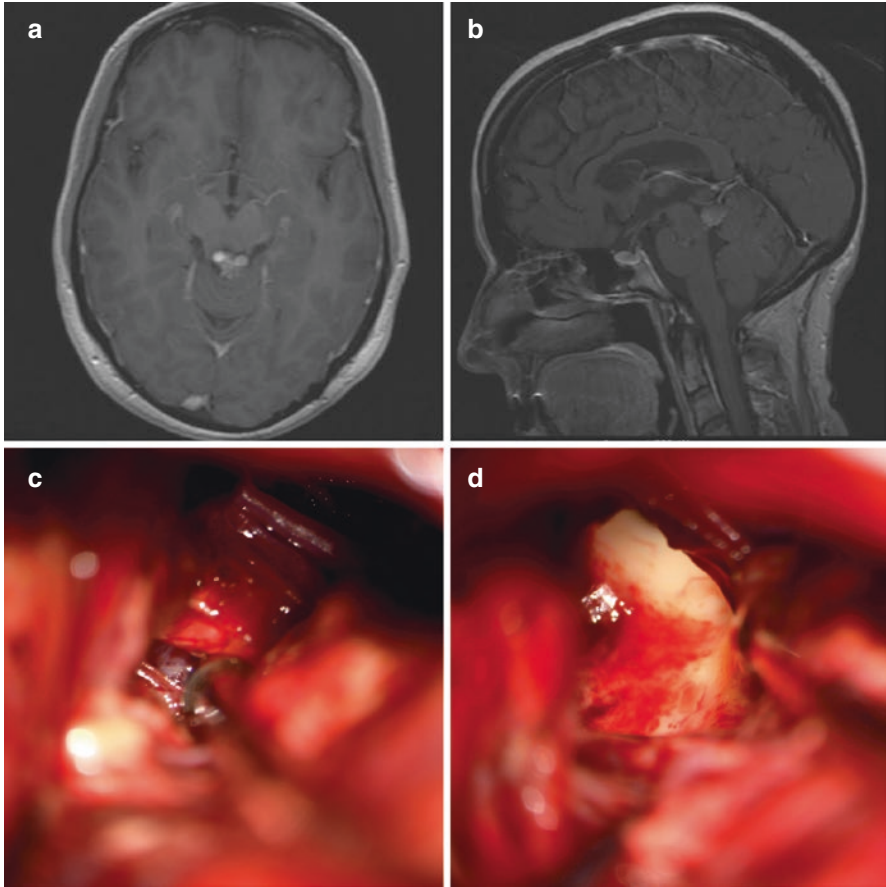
A patient presenting with diplopia and paresthesia was found to have a dorsal midbrain CM with a classic “popcorn” appearance on axial (a) and sagittal (b) MRI sequences. A supracerebellar-infratentorial craniotomy was planned to approach this lesion. Even with the patient in the sitting position, to maximize gravity retraction of the cerebellum, the CM was not completely visible. Resection of a small area of the medial cerebellar hemisphere exposed the lesion in the cerebellomesencephalic flexure (c). This partially exophytic CM enabled resection without transgression of normal brainstem (d). Used with permission from Barrow Neurological Institute
